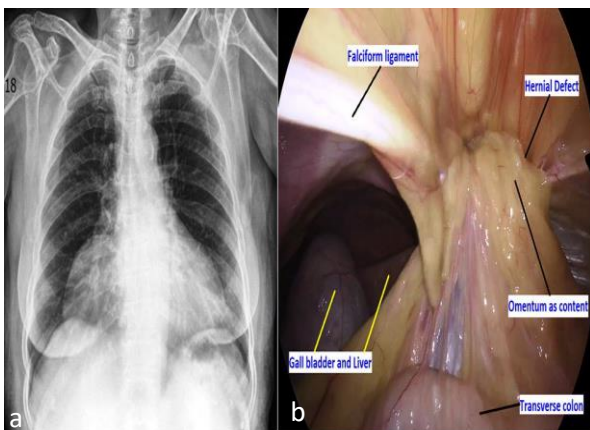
(a) Chest X-ray showing radiopaque shadow in right lower chest, (b) laparoscopic view of Morgagni hernia with content.
